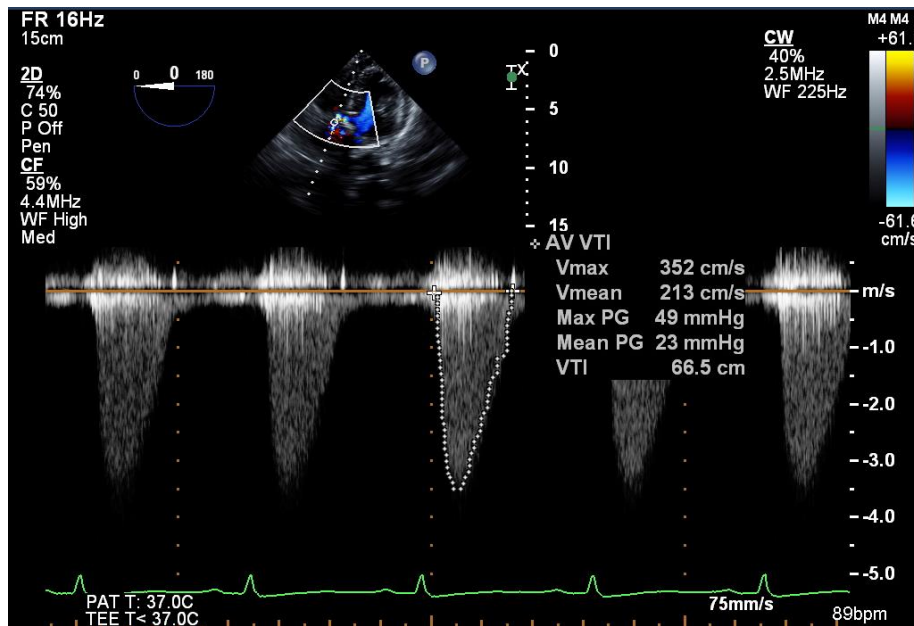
Tracing the CWD Doppler signal of AV for calculation of peak velocity and mean gradient
